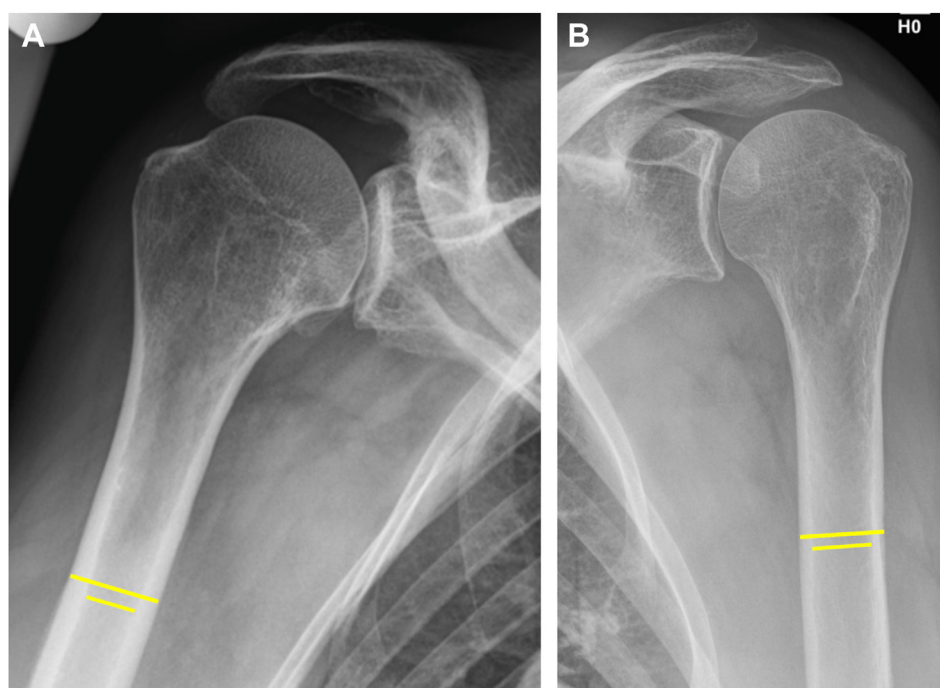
The deltoid tuberosity index (DTI) correlates with local bone mineral density (BMD) and is measured on anteroposterior radiographs of the shoulder (ratio between the outer cortical and inner endosteal diameter immediately above the deltoid tuberosity). Values lower than 1.4 indicate low BMD of the proximal humerus.³⁵ (A) A DTI >1.4 in a 72-year-old male patient. (B) A DTI >1.4 in a 63-year-old female patient.
